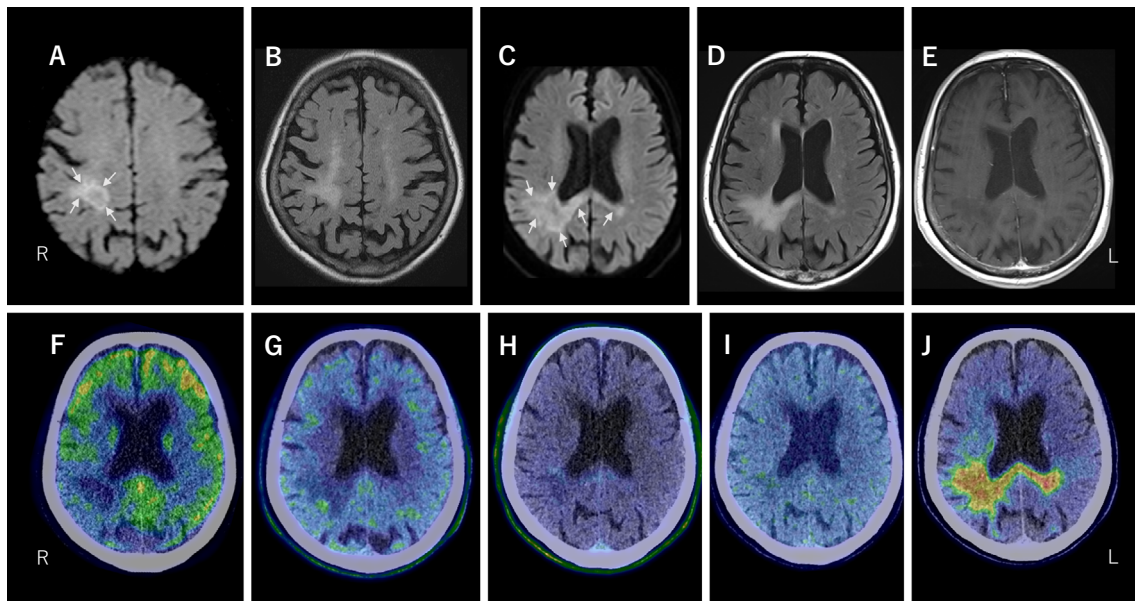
Brain MRI on day 4 (A, B) and 44 (C-E) after the onset. A, C: DWI showed intense hyperintensity at the edges of the lesion (*arrows*). B, D: FLAIR images revealed hyperintensity throughout the lesion. The lesion at the onset was confined to the upper right parietal lobe (A, B) and thereafter descended from the upper right parietal lobe and extended through the corpus callosum to the left parietal lobe (C, D). E: Gadolinium enhancement on T1-weighted imaging was not observed. PET imaging with ^{18}F -fluorodeoxyglucose (FDG) (F), ^{11}C -methionine (MET) (G), ^{18}F -fluoro-3'-deoxy-3'-L-fluorothymidine (FLT) (H), ^{18}F -fluoromisonidazole (FMISO) (I), and ^{18}F -THK5351 (J). Of these, only ^{18}F -THK5351-PET demonstrated a marked accumulation of ^{18}F -THK5351 consistent with the lesion on MRI. Panels F-J are merged PET and CT images.
